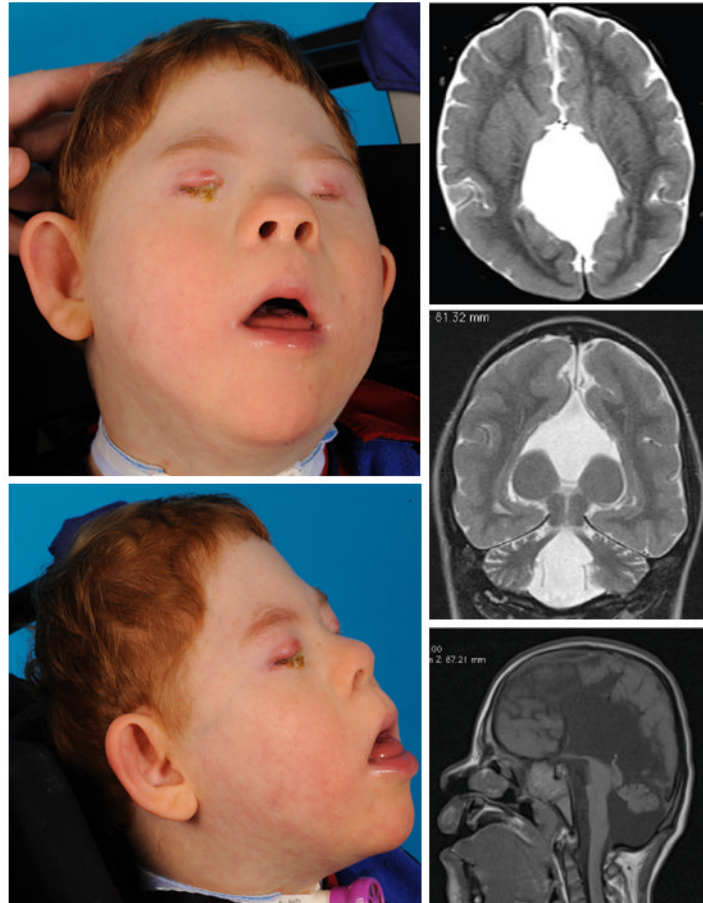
Propositus with compound heterozygosity for mutations in *PAX6*. Facial features were consistent with trisomy 21, and were also notable for extreme microcephaly, microphthalmia, and a smooth philtrum. Axial, coronal, and sagittal (from top) brain MRI demonstrates complex structural brain anomaly in propositus.
